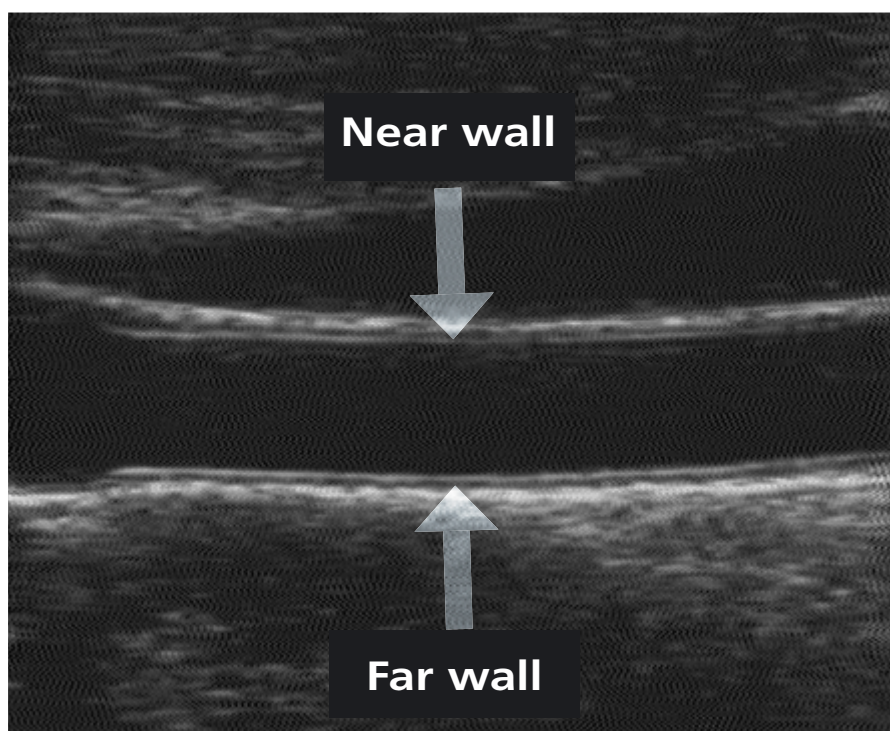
Longitudinal 2-D ultrasound image of the distal common carotid artery
